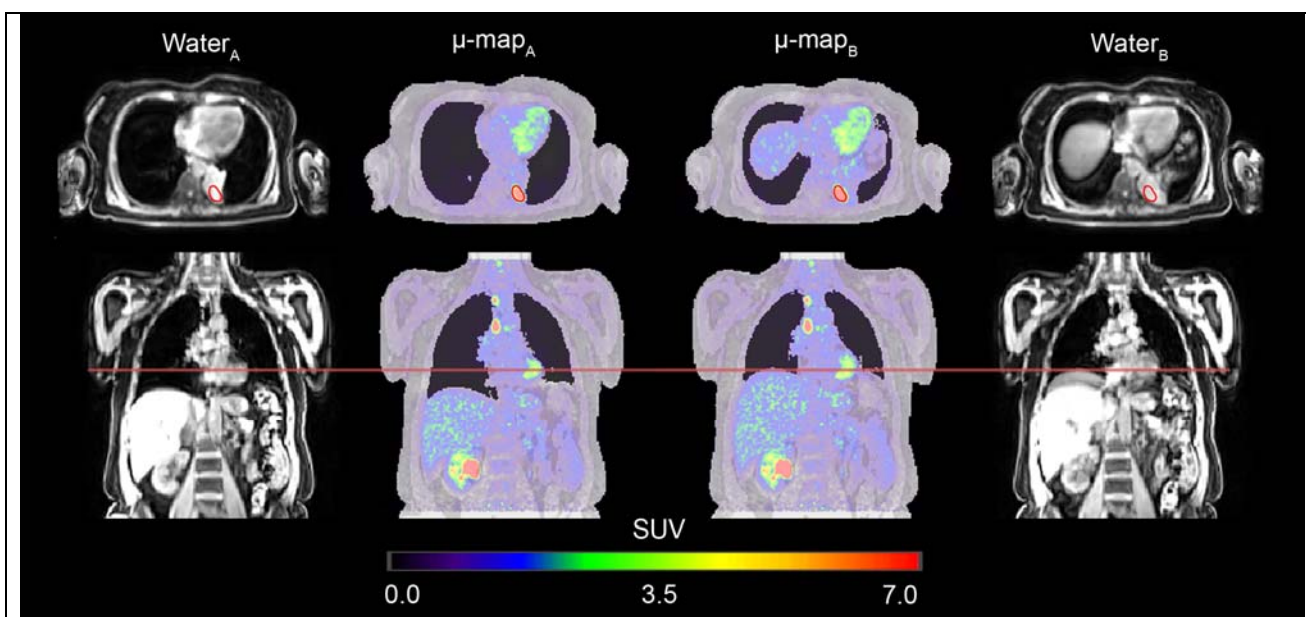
Patient 3, examination 2. Intra-subject repeated MR-AC maps ( $\mu\text{-map}_A$  and  $\mu\text{-map}_B$ ) fused with  $\text{PET}_A$  and  $\text{PET}_B$ , along with their respective Dixon water images. Initially, no artifacts were found to have an impact on the tumor SUV based on the visual evaluation of the MR-AC maps alone. However, from the corresponding Dixon water image of  $\mu\text{-map}_B$  respiration artifacts are apparent. A comparison of  $\mu\text{-map}_A$  and  $\mu\text{-map}_B$  shows a partially elevated diaphragm in  $\mu\text{-map}_B$  (red line) causing a  $\Delta\%SUV_{\max}$  of 27%.
